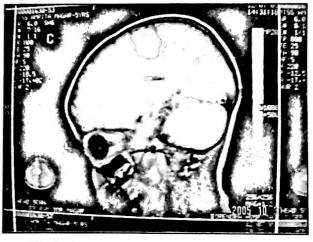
Preoperative contrast enhanced MRI brain.
